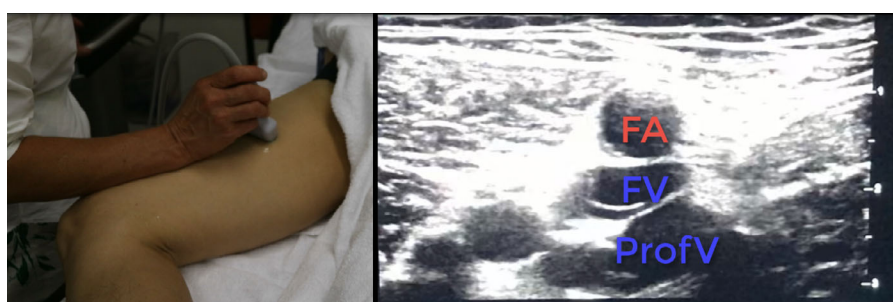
Positioning of the lower limb for compression ultrasound examination. Knee 20–30° bend and hip 30° externally rotated (frog's leg position) to allow full access to the medial part of the thigh and the popliteal fossa.
